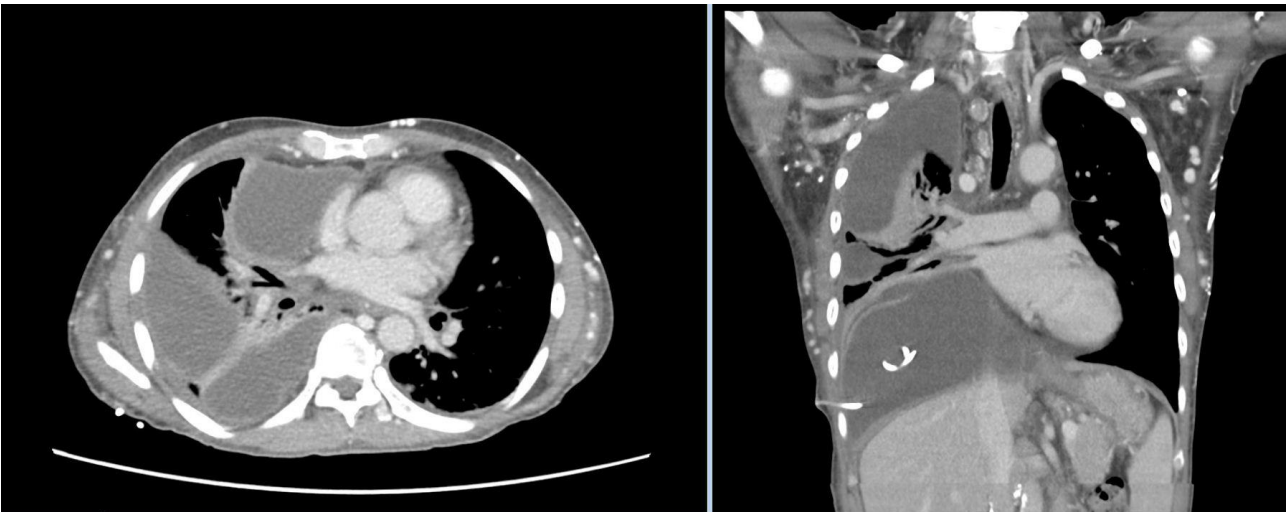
a,b. CT scan thorax axial view (a) showed multiloculated right-sided pleural effusion with split pleural sign. CT Scan thorax coronal view (b) revealed a multiloculated pleural effusion with chest drain in-situ at the right lower lobe
